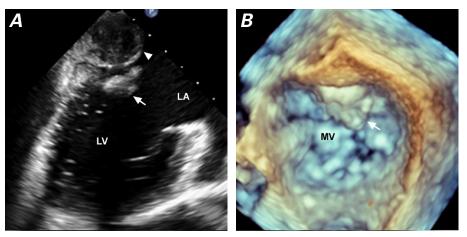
A) Two- and B) 3-dimensional transesophageal echocardiograms show vegetation on the posterior mitral valve leaflet (arrows) and reveal a retrocardiac mass (arrowhead).
